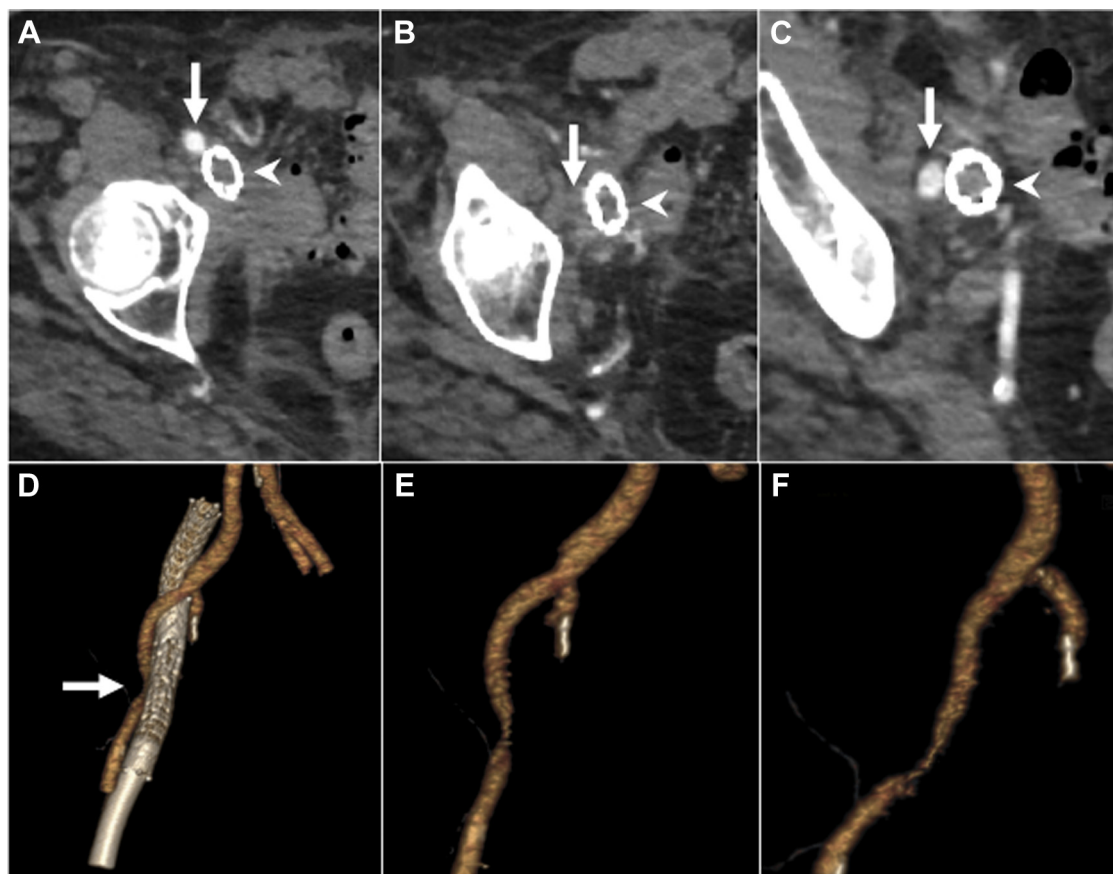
High-grade arterial stenosis after iliofemoral venous stent reconstruction. A-C, Sequential axial images from a pelvic computed tomographic angiography (CTA) through the site of pelvic side wall metastasis and venous Gianturco Z-stent buttressing show focal obliteration of the external iliac artery (EIA) (arrows) owing to extrinsic compression from both the venous stent construct (arrowheads) and tumor. There is normal opacification of the EIA immediately distal to the obstruction. The level of obliteration corresponds with the adjacent Venovo and Gianturco Z-stent (B; arrowhead). D, Three-dimensional reconstruction from pelvic CTA showing high-grade EIA stenosis (arrow). E, Anteroposterior and (F) 30° left anterior oblique views, with stent subtracted, showing concentric, near-occlusive, EIA stenosis.
